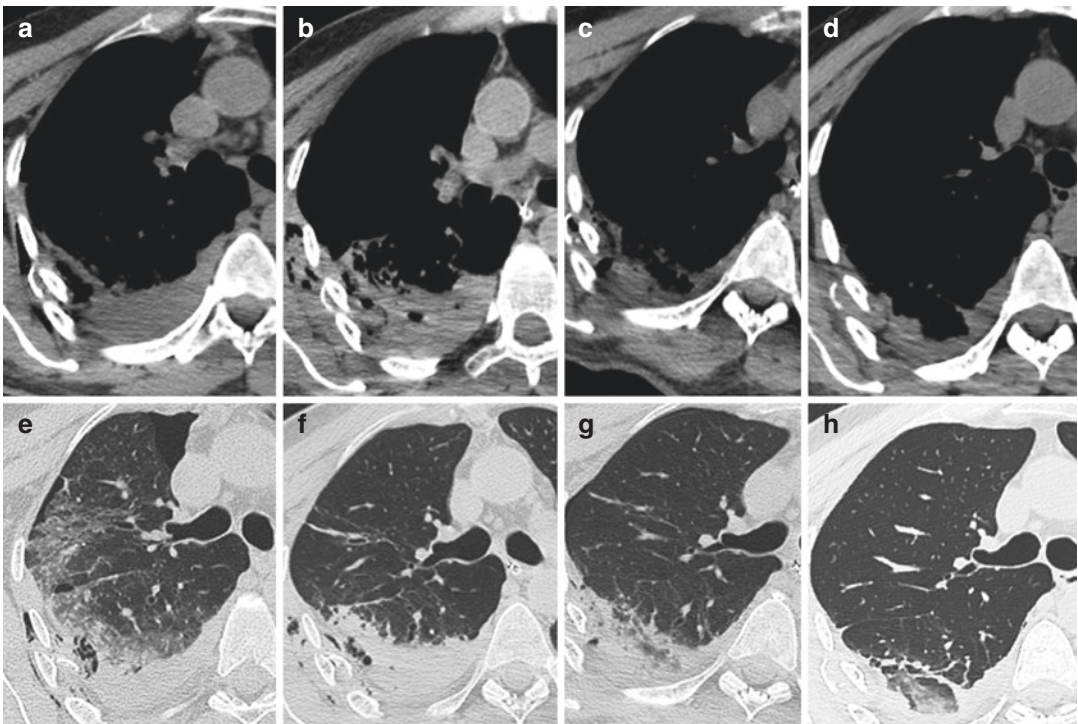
Axial CT-images show contusions and type 3 lacerations (*arrow*). Immediately after trauma (a-e) the lacerations are small peripheral and associated with local rib fractures, pneumothorax, and chest wall emphysema.
